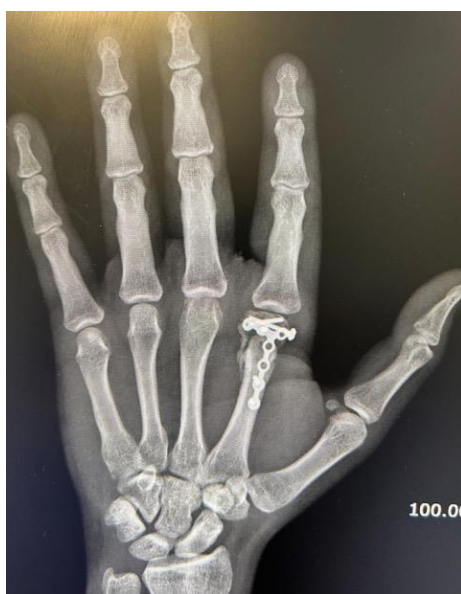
X-ray at 1-month follow-up.
